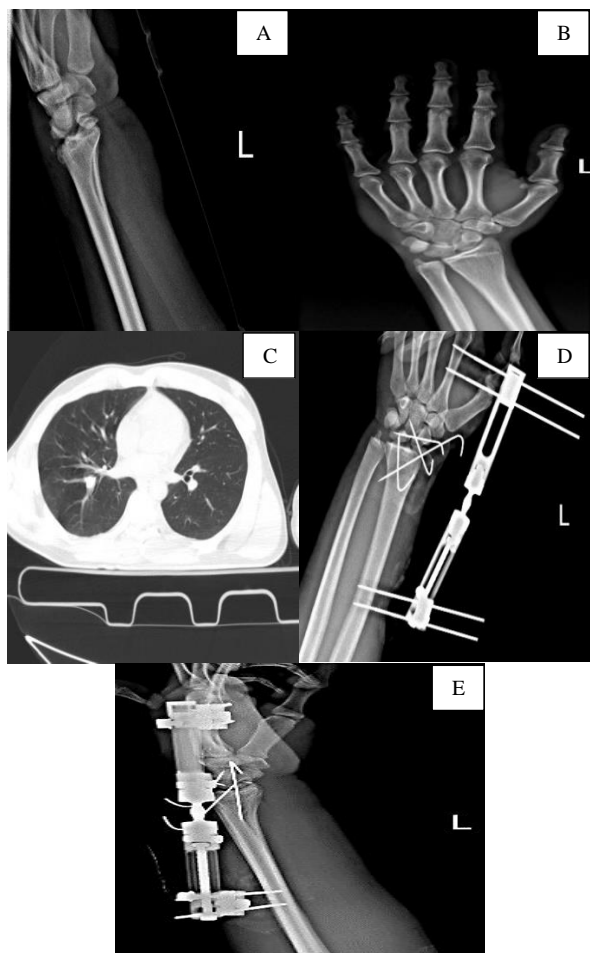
Case 1: A and B) preoperative radiographs of the patient, C) chest computed tomography (CT) scan, D and E) postoperative radiographs
